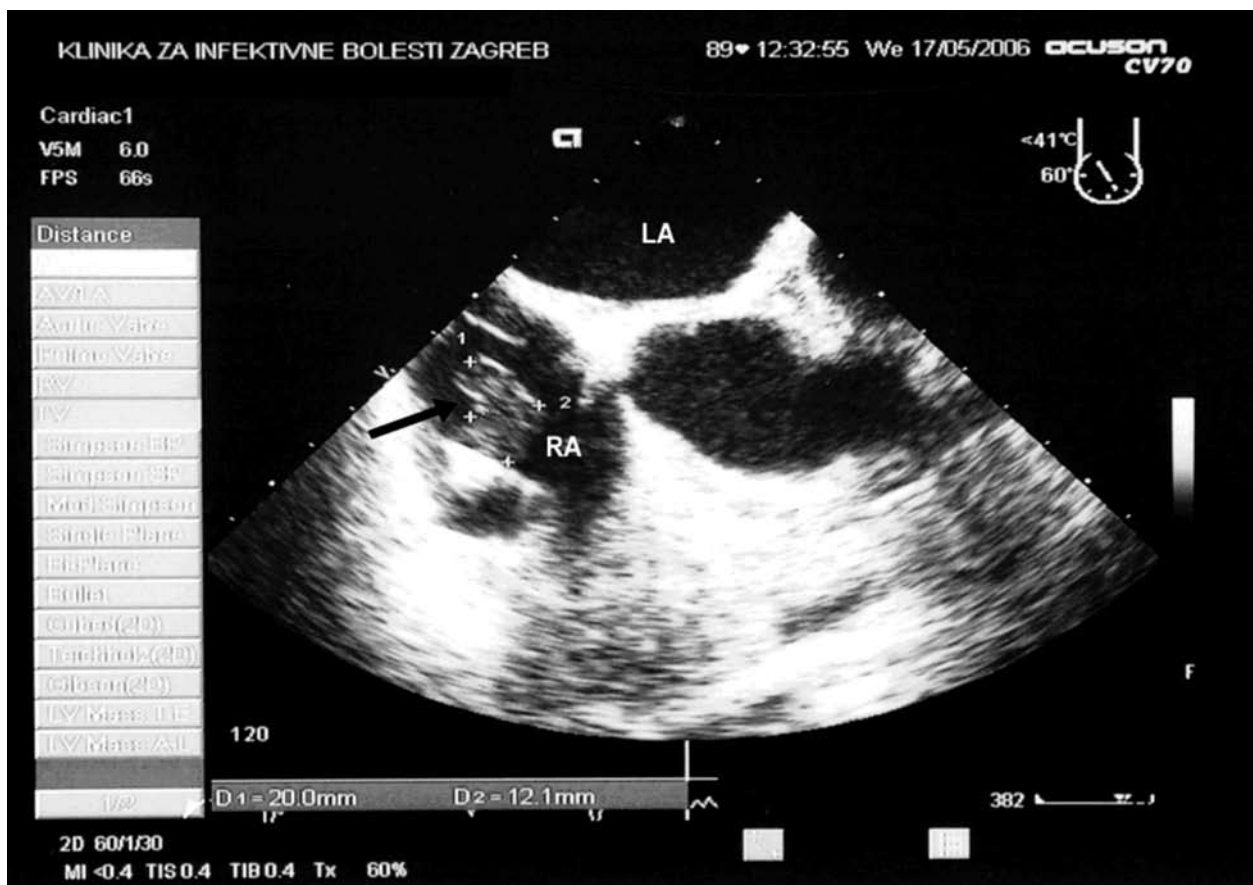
Transesophageal echocardiogram showing large vegetation attached to the implantable cardioverter defibrillator lead in the right atrium (arrow); RA, right atrium; LA, left atrium.
